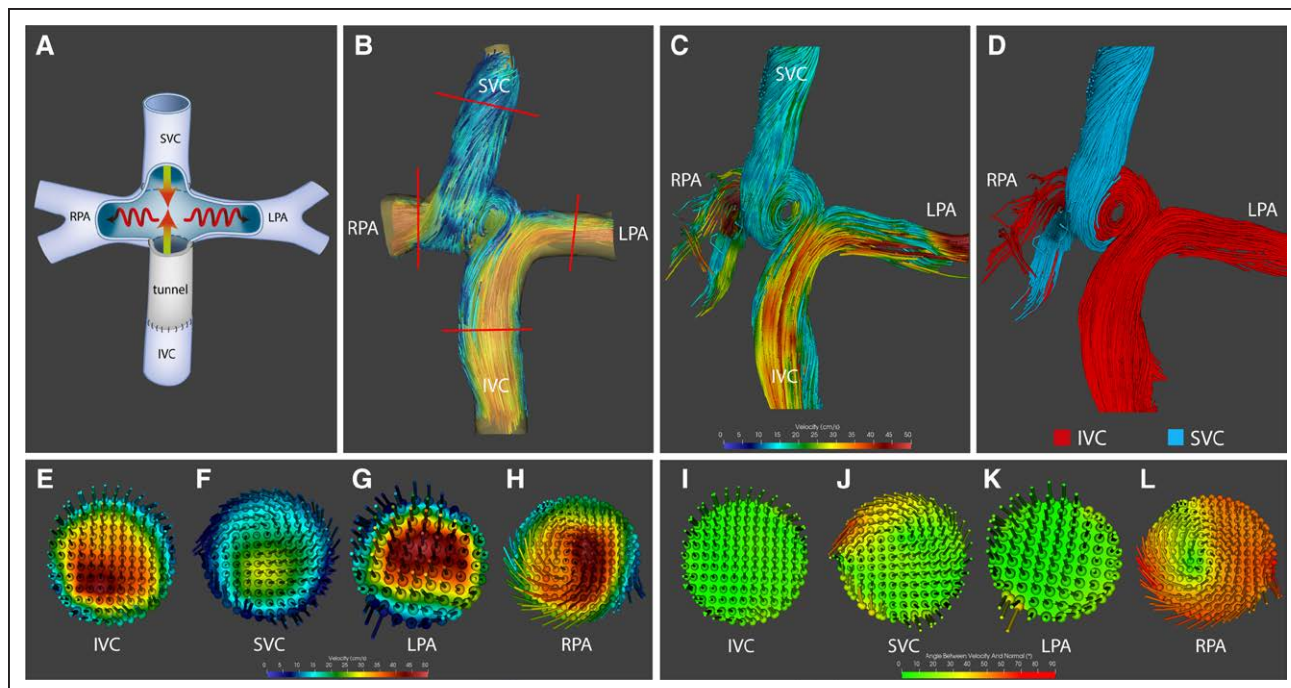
Visualization of abnormal blood flow patterns in the TCPC with 4D MRI.
